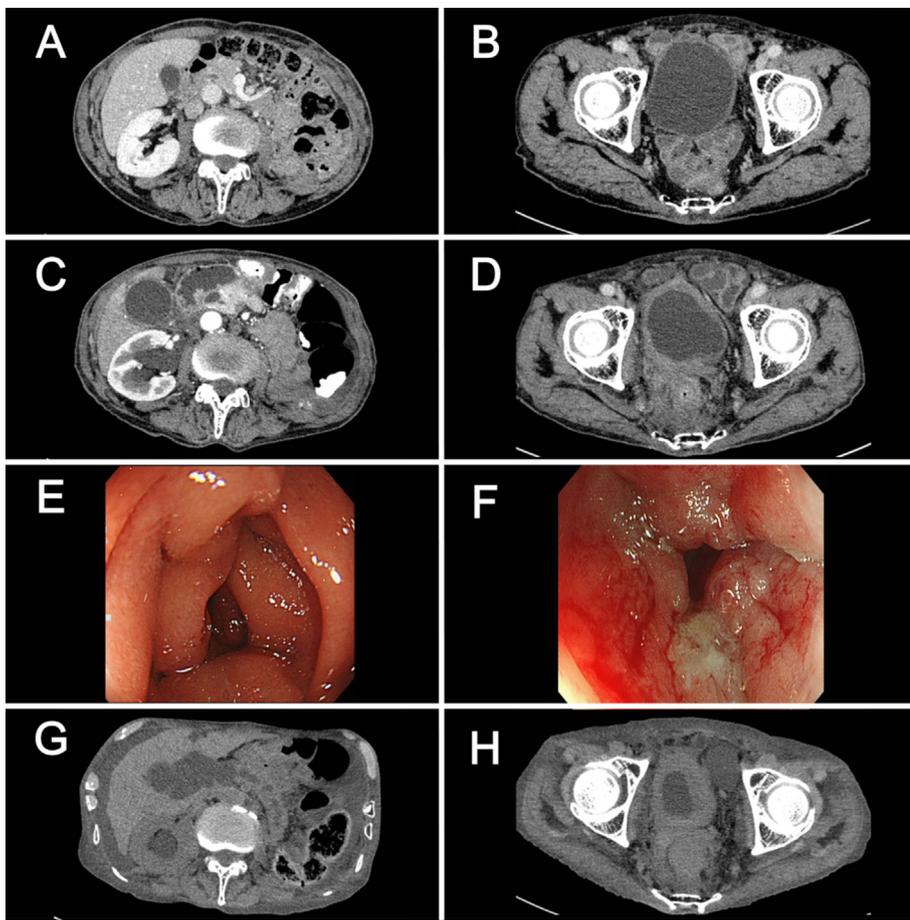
Abdominal computed tomography and gastrointestinal endoscopy. Abdominal computed tomography seven months before the visit (A, B), at the visit (C, D). Duodenal obstruction and moderate hydronephrosis are revealed, but no tumor and no lymph node enlargement are revealed. Upper gastrointestinal endoscopy showing narrowing of the duodenal lumen due to oppression from the outside of the intestinal tract (E). Duodenal mucosa biopsy did not detect malignancies. Lower gastrointestinal endoscopy showing narrowing of the rectal lumen (F). Rectal mucosa biopsy did not detect malignancies. Abdominal computed tomography before his death (G, H). The thickness of the bladder wall and rectal wall with thickening of the surrounding tissue worsened as the disease progressed. Visceral metastases (e.g., lung, liver, and bone) or lymph node enlargement suggesting lymphatic metastasis did not occur, even by the last CT.
